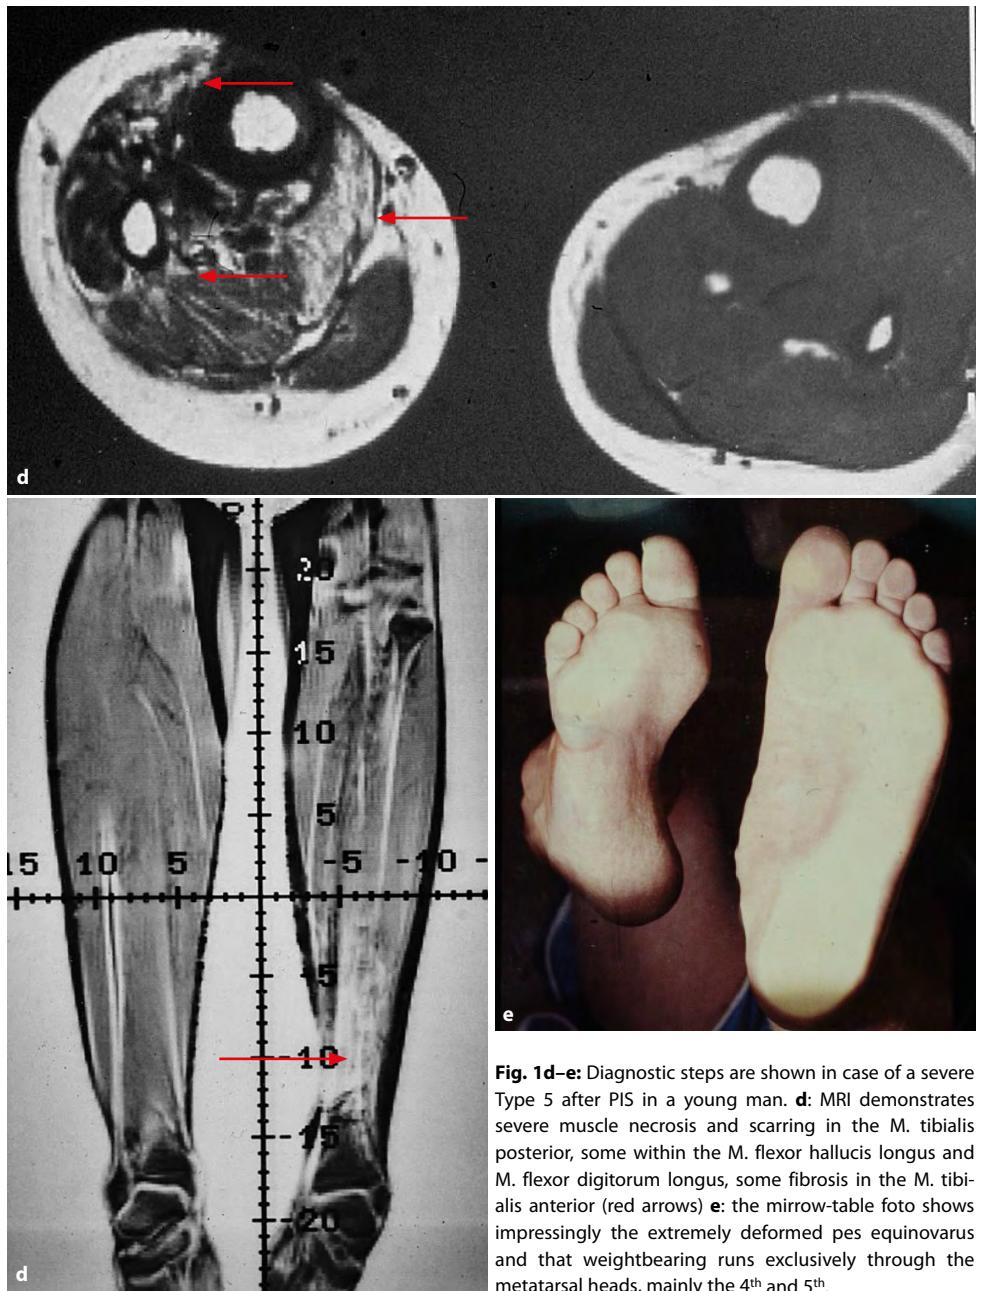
Diagnostic steps are shown in case of a severe Type 5 after PIS in a young man. d: MRI demonstrates severe muscle necrosis and scarring in the M. tibialis posterior, some within the M. flexor hallucis longus and M. flexor digitorum longus, some fibrosis in the M. tibialis anterior (red arrows) e: the mirror-table foto shows impressingly the extremely deformed pes equinovarus and that weightbearing runs exclusively through the metatarsal heads, mainly the 4th and 5th.
